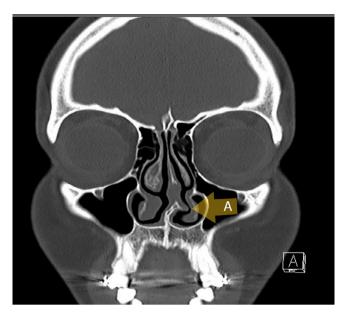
Intermittent MCP with indentation sign On CT sinus (arrow). MCP, mucosal contact point
